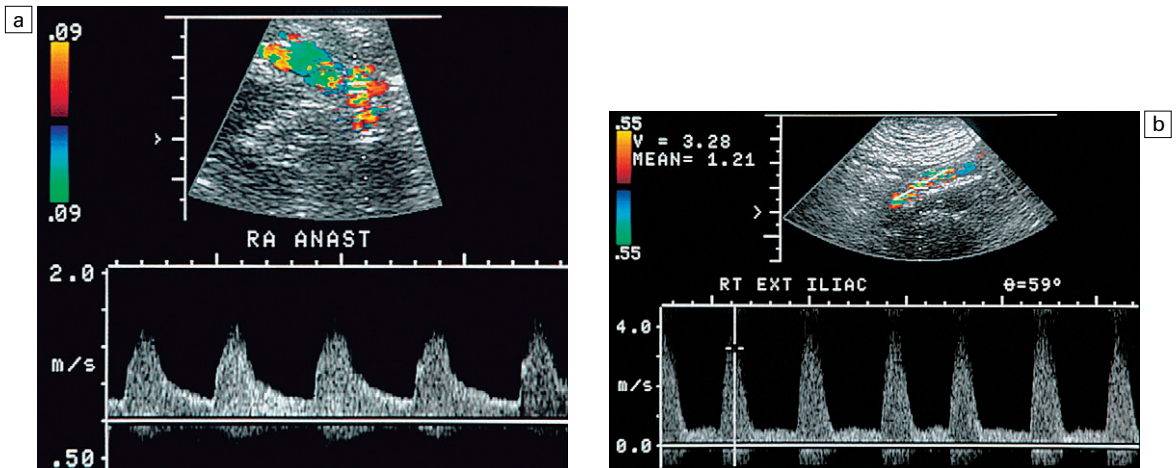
(a) Spectral Doppler tracing of a transplant main renal artery. Tardus parvus changes were present in this waveform but no anastomotic stenosis was perceived. (b) Spectral Doppler tracing of the external iliac artery. A high-velocity jet is identified with velocities of $>3 \text{ m s}^{-1}$. This diabetic recipient had an atheromatous lesion in the iliac artery compromising inflow to the renal transplant.
